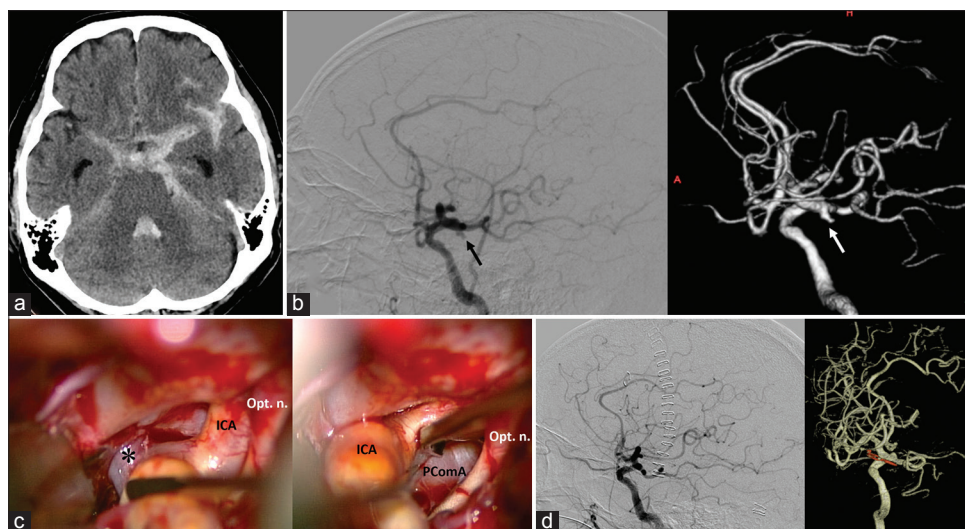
(a) Computed tomography obtained 7 years after transient right internal carotid artery occlusion revealing subarachnoid hemorrhage. (b) Angiography demonstrating a left internal carotid-posterior communicating artery aneurysm (arrow). (c) Intraoperative photograph showing the aneurysm (asterisk) and the thick posterior communicating artery running toward the medial side. (d) Postoperative angiography demonstrating complete clipping of the internal carotid-posterior communicating artery aneurysm
